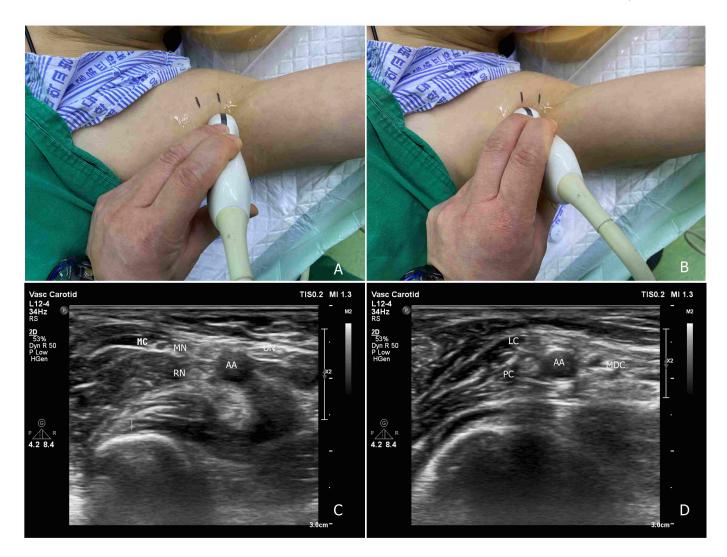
Ultrasound images of the brachial plexus and the position of the ultrasound probe. (A) brachial plexus with four nerve branches, including the median (MN), ulnar (UN), radial (RN), and musculocutaneous (MC) nerves. (B) Brachial plexus with three cords: the lateral cord (LC), medial cord (MDC) and posterior cord (PC). (C): Ultrasound image of Fig. 1A. (D) Ultrasound image of Fig. 1B.
